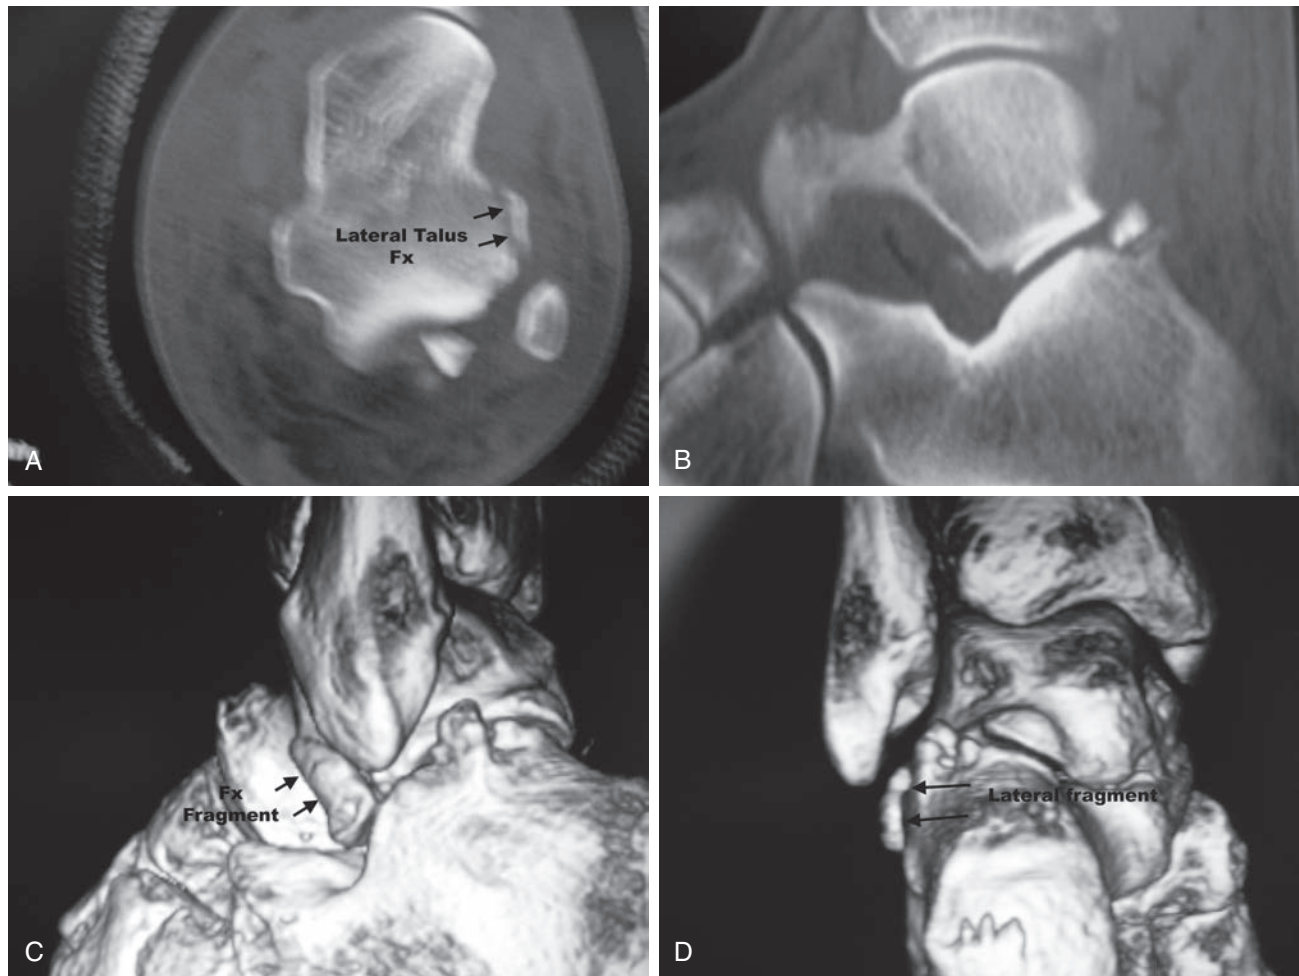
Axial computed tomography scan of talus demonstrating lateral process fracture that was not identified on ankle radiographs in athlete.
